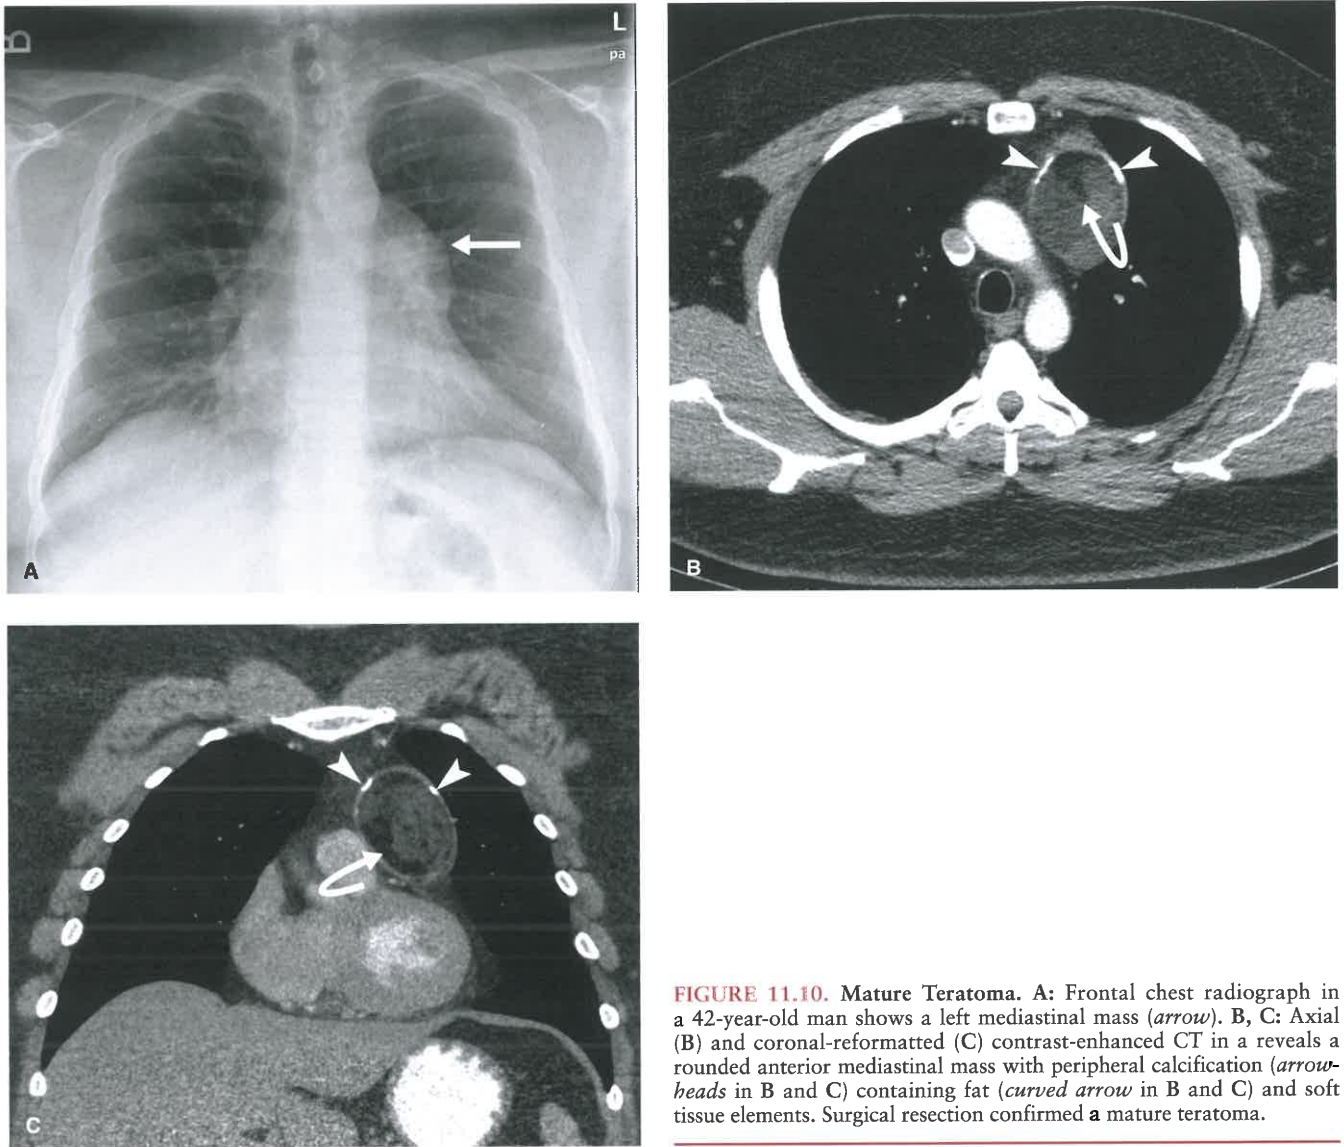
Mature Teratoma. A: Frontal chest radiograph in a 42-year-old man shows a left mediastinal mass (*arrow*). B, C: Axial (B) and coronal-reformatted (C) contrast-enhanced CT in a reveals a rounded anterior mediastinal mass with peripheral calcification (*arrowheads* in B and C) containing fat (*curved arrow* in B and C) and soft tissue elements. Surgical resection confirmed a mature teratoma.
